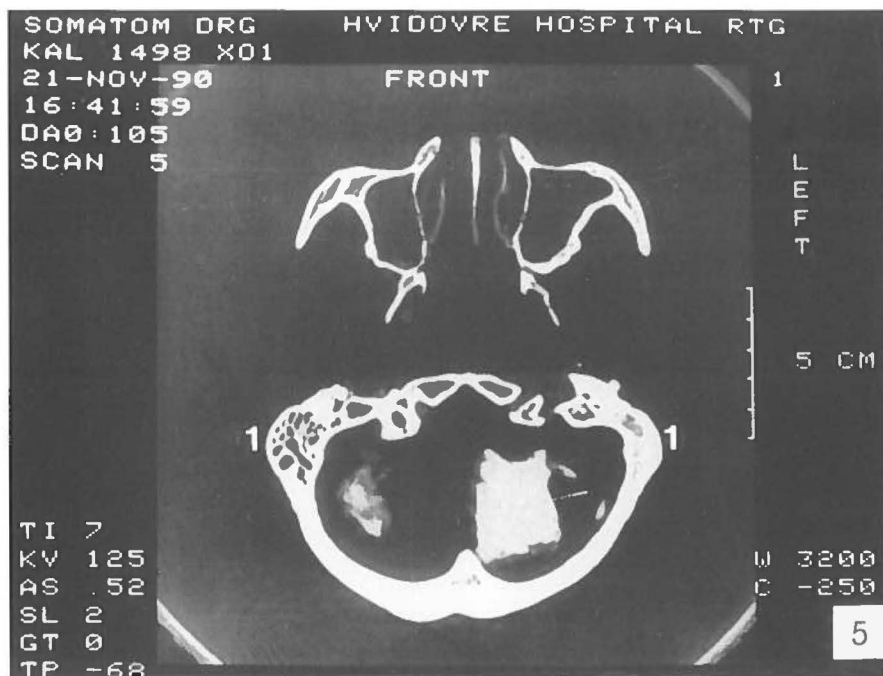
CT-scan at the mastoid level (1) of cranium no. 3. The left side is sclerosed.
